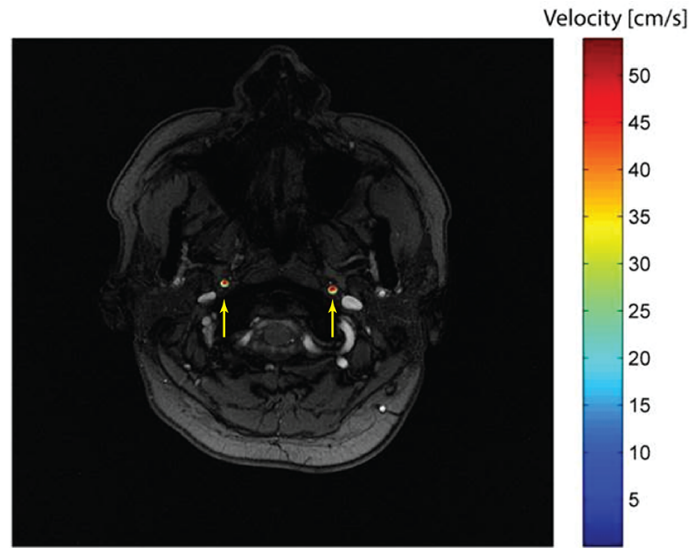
Example of the transverse plane of PC MRI of a healthy adult. Carotid arteries are pointed by the arrows, and the blood velocity can be computed from the signal intensity of the PC MRI (VENC=80cm/s).
